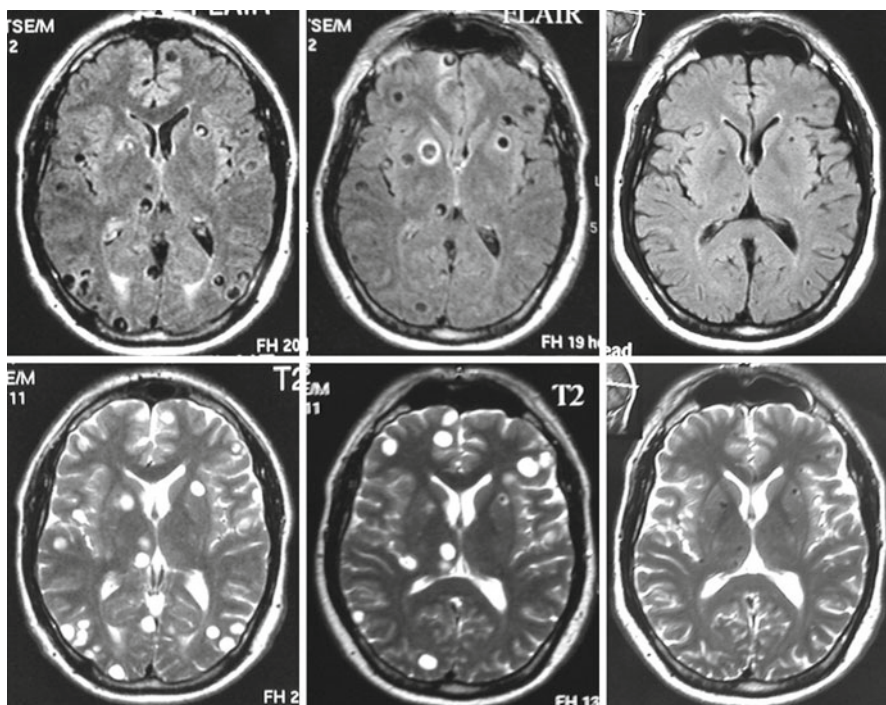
Fluid-attenuated inversion recovery (FLAIR) and T2-weighted MRI showing multiple parenchymal brain cysticerci in the vesicular stage (*left*). Three months after albendazole therapy, most lesions—particularly those located at the occipital lobes—disappeared (*center*), and 1 year after therapy, all lesions have been resolved and many of them have been replaced by a residual calcification (*right*)
